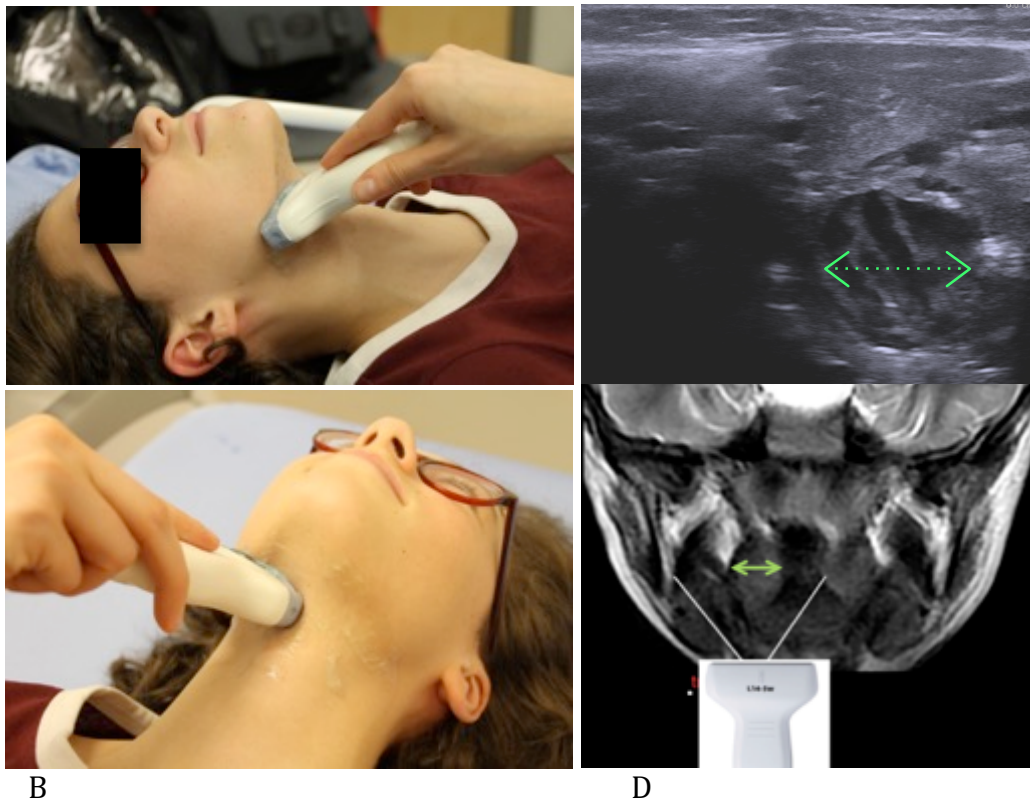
Transverse acquisition of the tonsil, showing medio-lateral axis. A. Demonstration of the positioning of the probe in order to obtain the transverse view on the tonsil. B. A second view of the probe positioning, still in the transverse acquisition. C. Ultrasound image of the tonsil in the transverse plane, green arrow is the medio-lateral axis. D. Equivalent MRI image of the tonsil, same color scheme as above.
